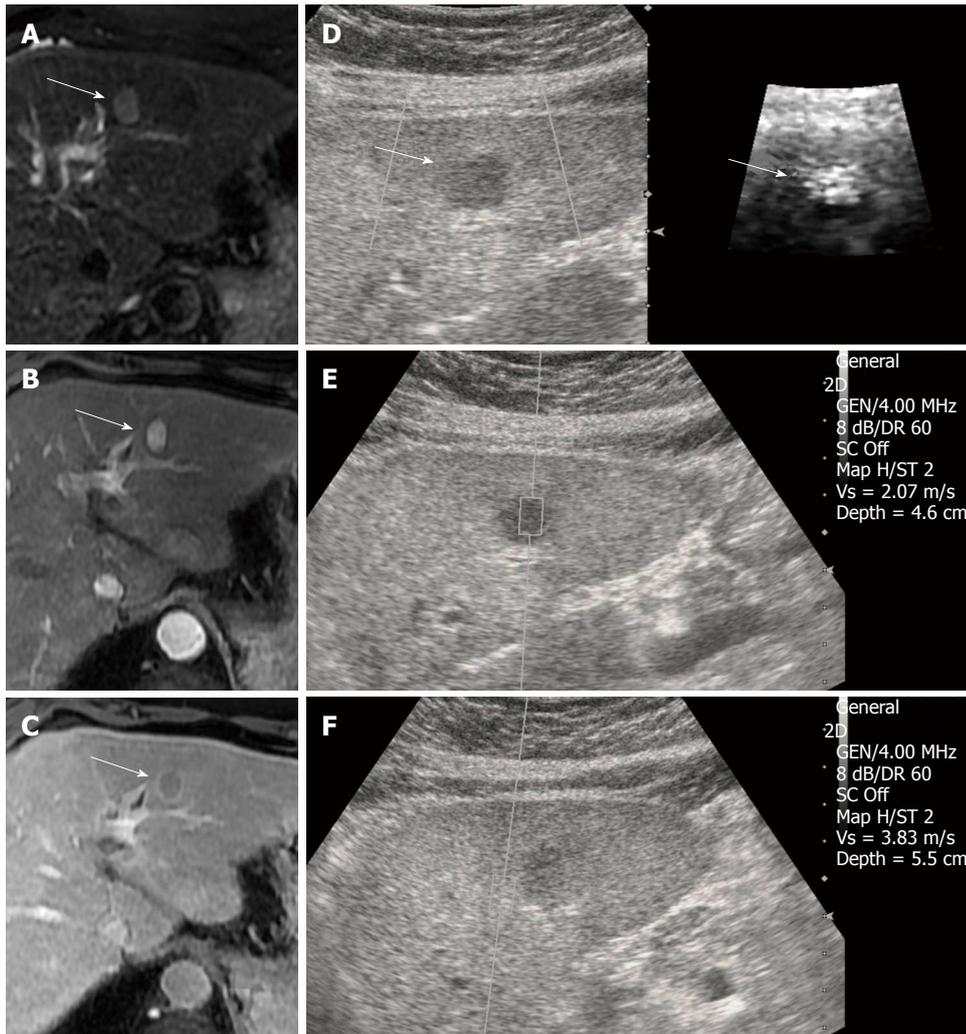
Hepatocellular carcinoma in a 59-year-old man with underlying liver cirrhosis. A: T2-weighted magnetic resonance (MR) image shows a high signal intensity mass in segment 2 of the liver (arrow); B: On dynamic study, the mass revealed an arterial enhancement; C: Delayed wash-out, which is a typical finding of hepatocellular carcinoma (HCC) (arrow); D: On B-mode image, the HCC appears as a well defined, hypoechoic mass and the HCC have a bright (softer) color on the acoustic radiation force impulse (ARFI) image (arrows); E: The shear wave velocity (SWV) of HCC is 2.07 m/s; F: SWV of surrounding cirrhotic hepatic parenchyma measures 3.83 m/s. GEN: General; SC: Spatial compounding; Vs: Velocity.
